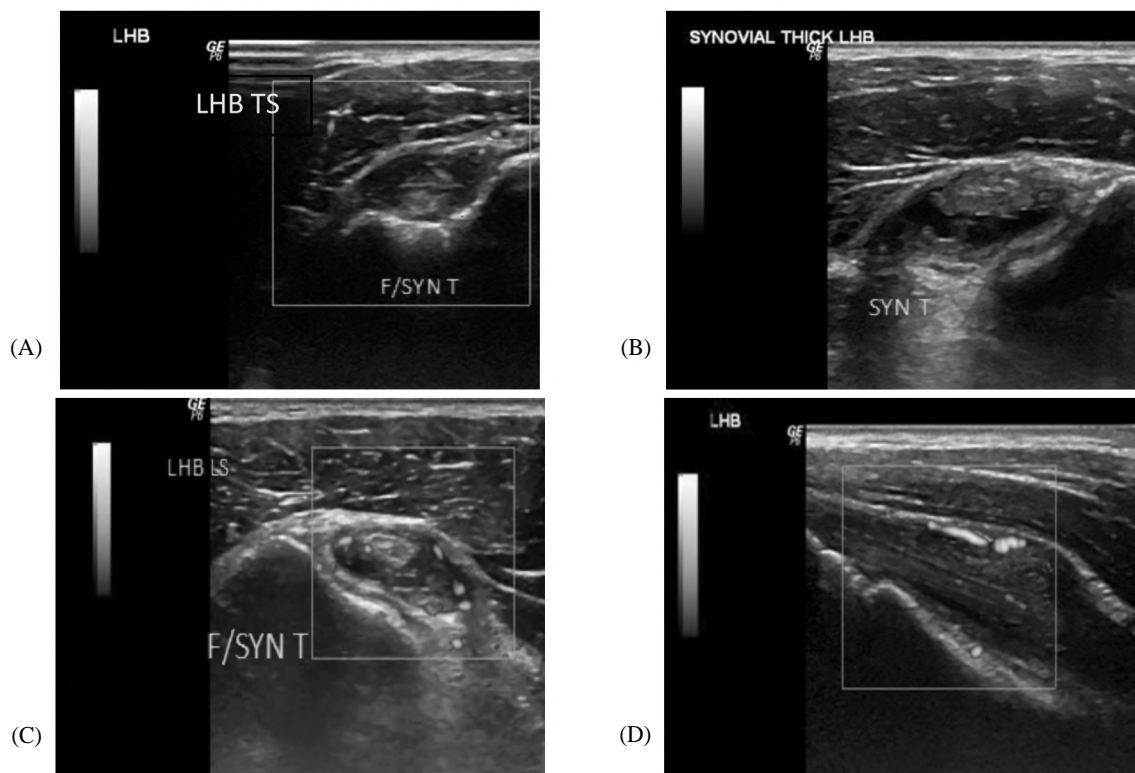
Power Doppler ultrasonography TS (A) and B mode (B) showed synovial thickening (SYN T) grade 3 (3 mm), synovial effusion (F) and increased vascularity. Follow-up by Power Doppler ultrasonography TS, LS (d) showed evidence of stationary synovial thickening (SYN T) grade (3 mm), synovial fluid (F) and vascularity with long head of biceps (LHB) tenosynovitis (d) without improvement.
